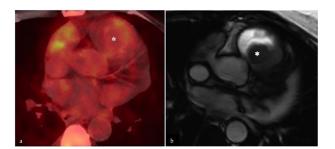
18F-FDG PET/CT imaging (a) compared to steady-state free-precession cine CMR imaging (b). The mass located in the subvalvular right ventricular outflow tract (*) does not show an abnormal 18F-FDG uptake, while it is clearly depicted at CMR imaging.
